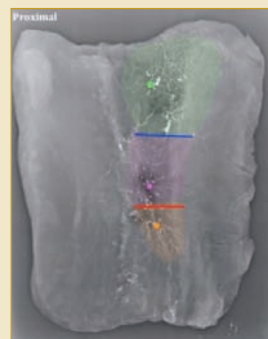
A lead oxide radiographic study (coloured using photoshop) showing three vascular territories of the gracilis pedicles with intervening choke zones
